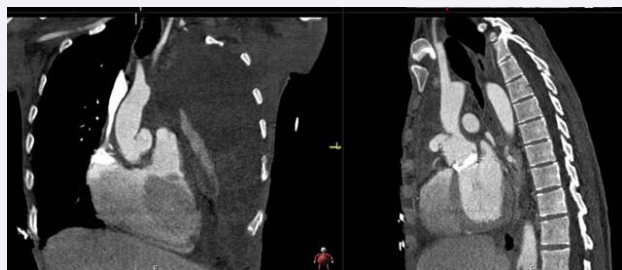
3-dimensional rendering of chest CT-angiogram showing a mycotic aneurysm.
